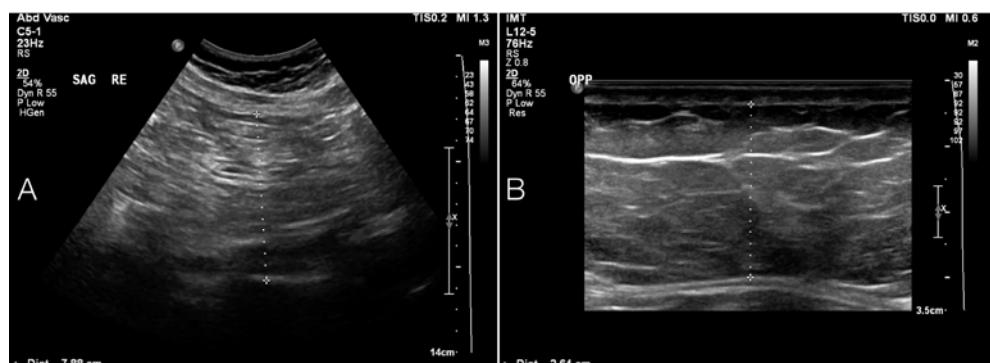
Ultrasonography is well suited for distinguishing subcutaneous and intraabdominal adipose tissue.
